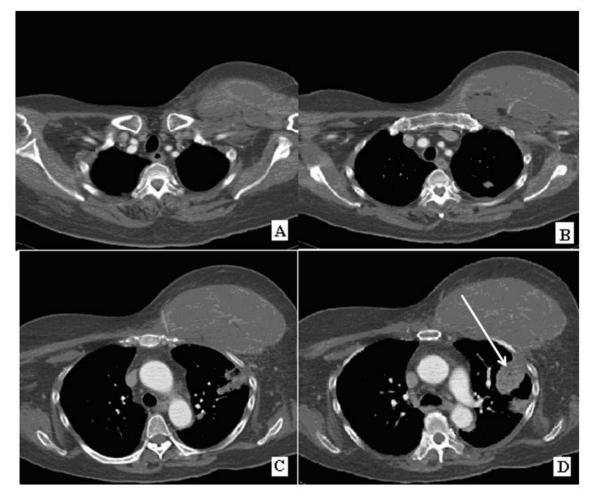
CT thorax shows increasing numbers and size of the left upper lobe lesions. There is a large collection in the left chest wall. The mass is at the needle tract of the PTNB (arrow).
